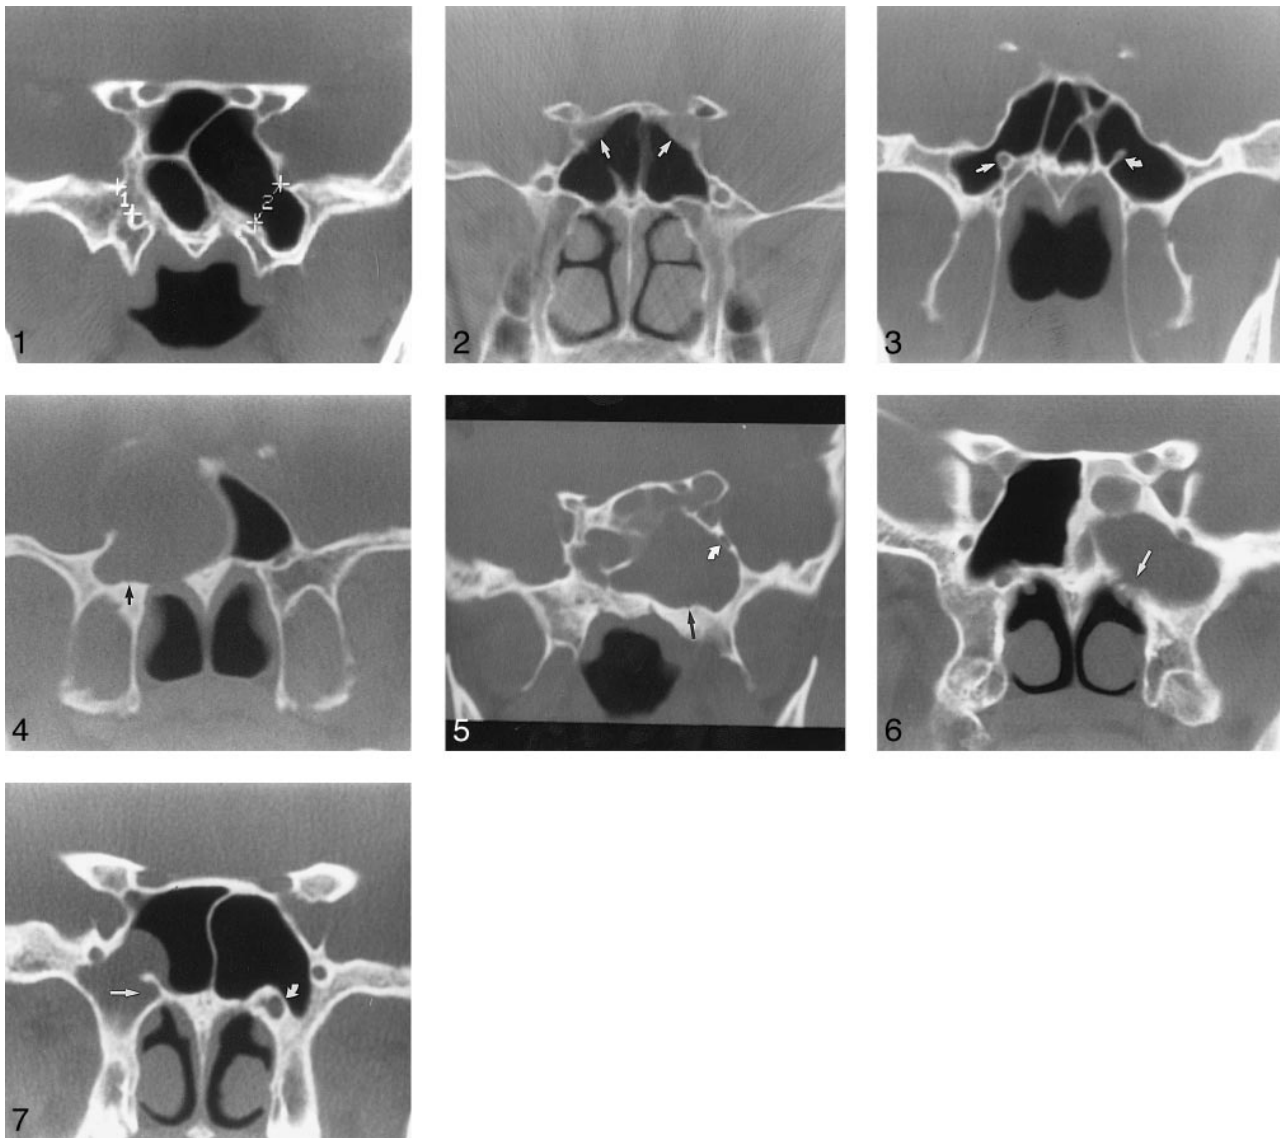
Coronal CT of a control subject. Measurement of the vidian-rotundum distance with electronic calipers shows a nonpneumatized greater sphenoid wing on the right (*caliper 1*), and a pneumatized greater sphenoid wing on the left (*caliper 2*). The vidian-rotundum distance was measured from the nearest bony margin of each canal, whether the foramen rotundum was visible on the coronal image as a semicircle, as noted in this subject, or as a complete ring.
